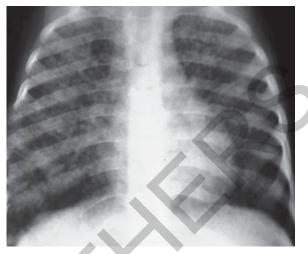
Chest X-ray of a 2.5-year-old girl with miliary tuberculosis.
